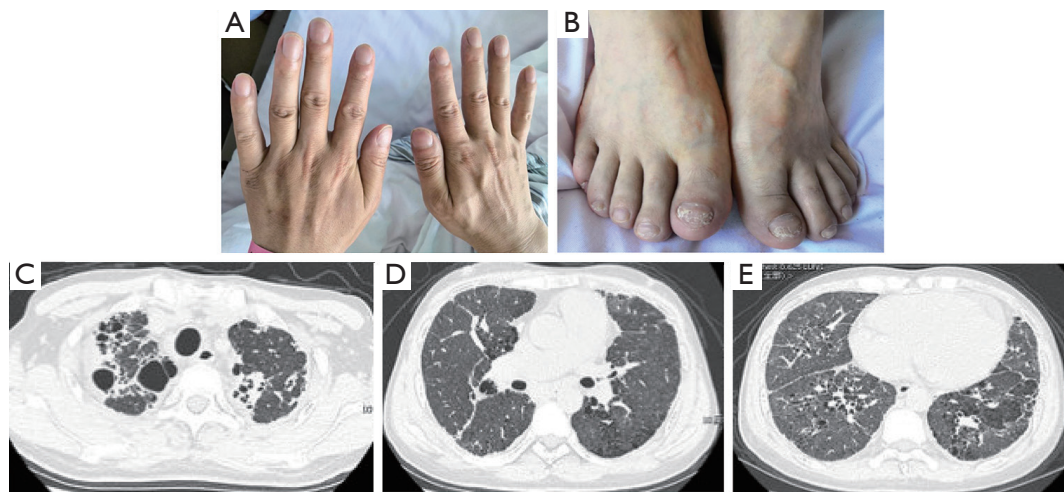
Clinical manifestations and chest image of case 1. (A) Clubbing fingers of case 1. (B) Nail dystrophy of toes in case 1. (C-E) Chest high-resolution computed tomography scan of case 1. The presence of cystic airspaces in upper lobes, and bilateral reticular and ground-glass opacities in the lower lobes in case 1.
